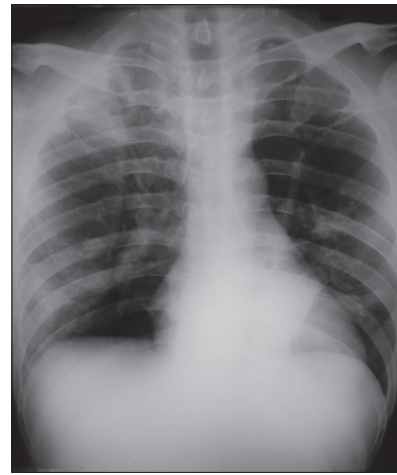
Chest radiograph showing alveolar opacities in the right upper, middle, and both lower zones
